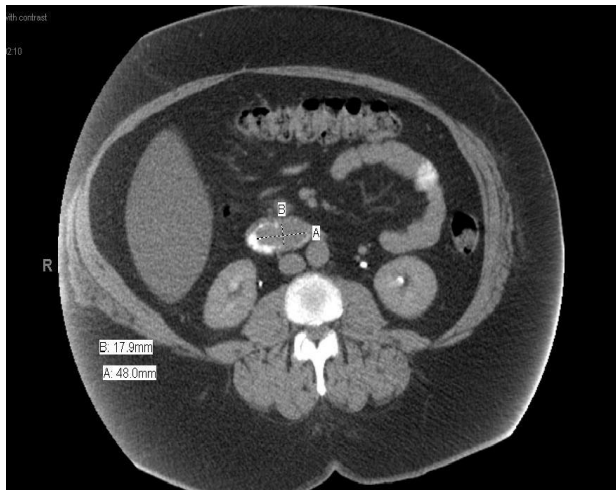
CT scan figure with intravenous and oral contrast showing 17.9 x 48 mm filling defect in the third portion of the duodenum causing an upper gastrointestinal obstruction. No evidence of lymph nodes or adjacent organ metastasis seen.
